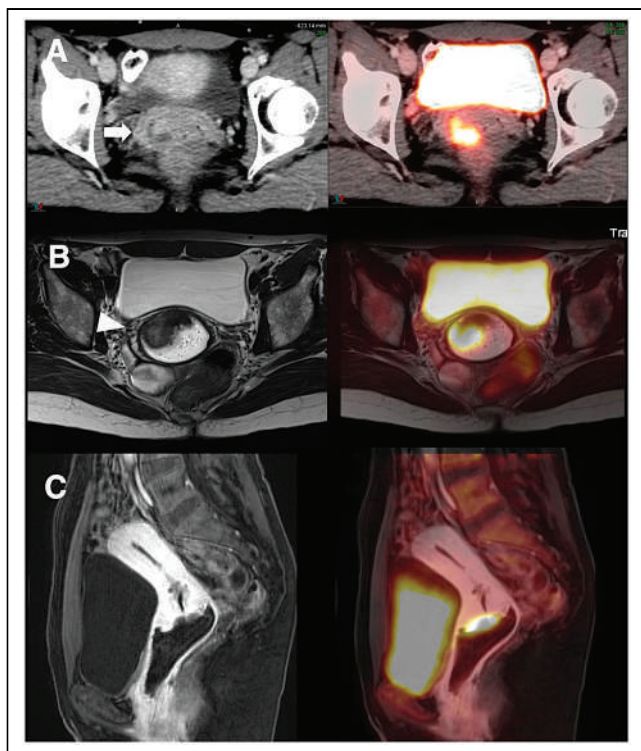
Poorly differentiated squamous cell carcinoma of cervix on CT (A, left) and PET/CT (A, right), with corresponding unenhanced T2-weighted turbo spin-echo CT (B, left) and T2-weighted turbo spin-echo PET/MRI (B, right) and contrast-enhanced sagittal MRI T1-weighted MRI (Dixon-visual background extractor sequence) (C, left) and PET/MRI (C, right). (Reprinted from (32).)
